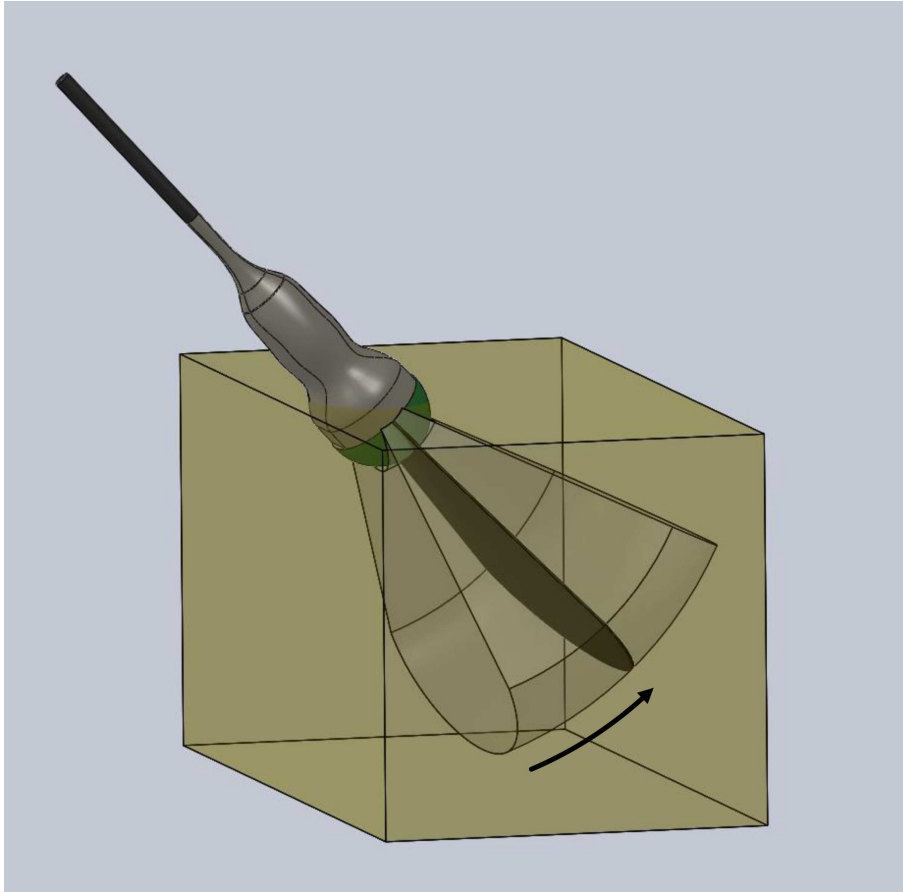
Shows the 3D US scan at a particular pose overlaid with the CT. The positions from the US are found in the CT, and the values are interpolated to create the inverse scan converted CT.
